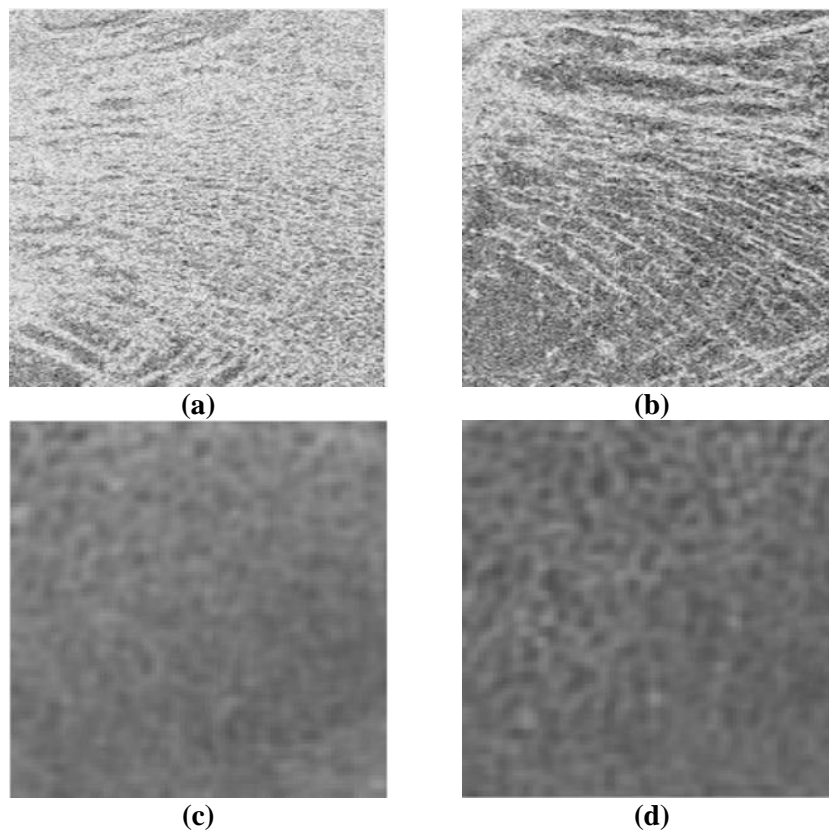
Extracted healthy and pathological ROIs: (a): Healthy MRI, (b): Osteoporosis MRI, (c): Healthy X-Ray image and (d): Osteoporosis X-Ray image.
